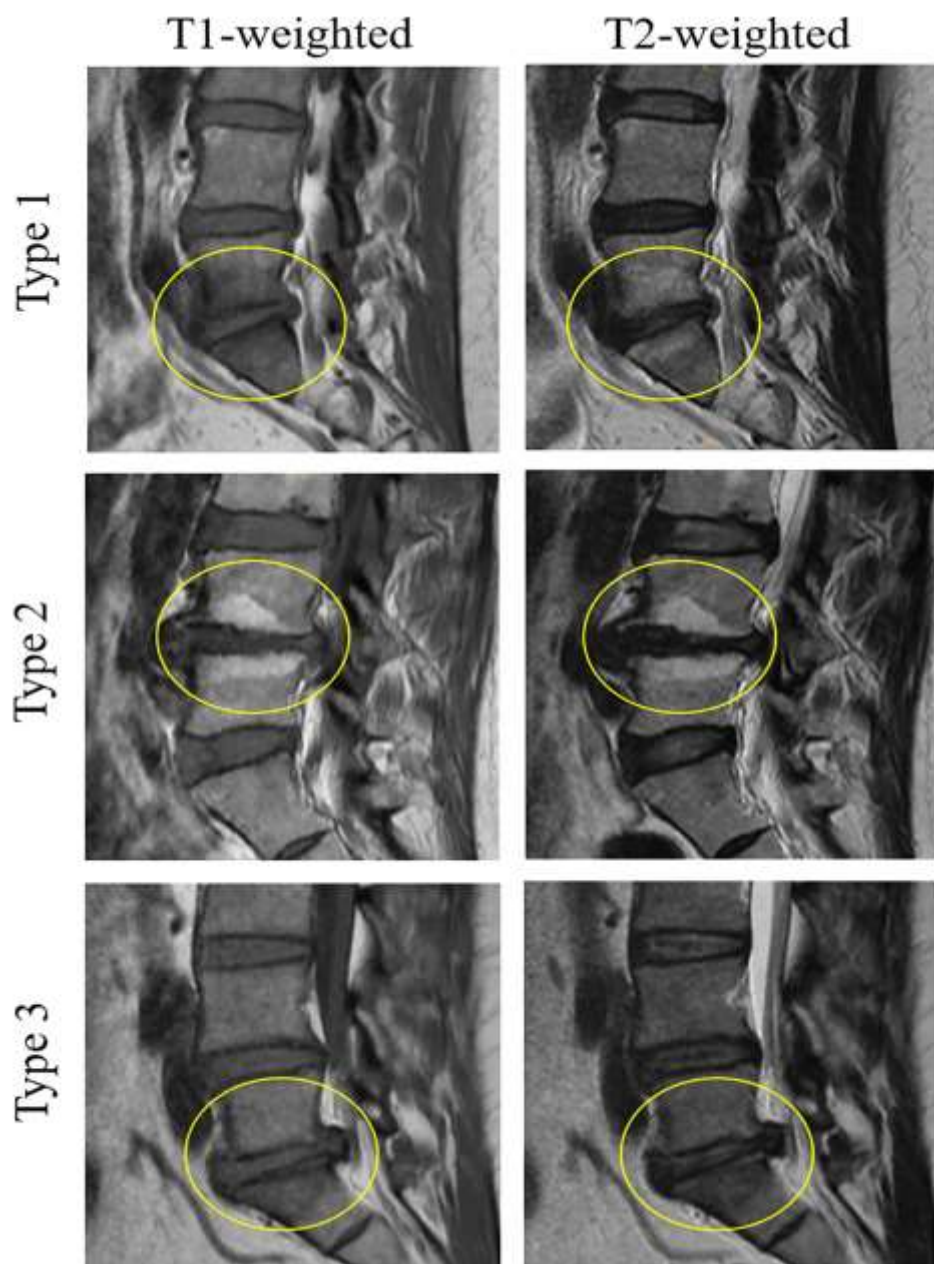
Examples of Modic changes (MC). Circled regions denote Type 1, Type 2, and Type 3 MC in accordance to their signal intensities upon sagittal MRI images.
